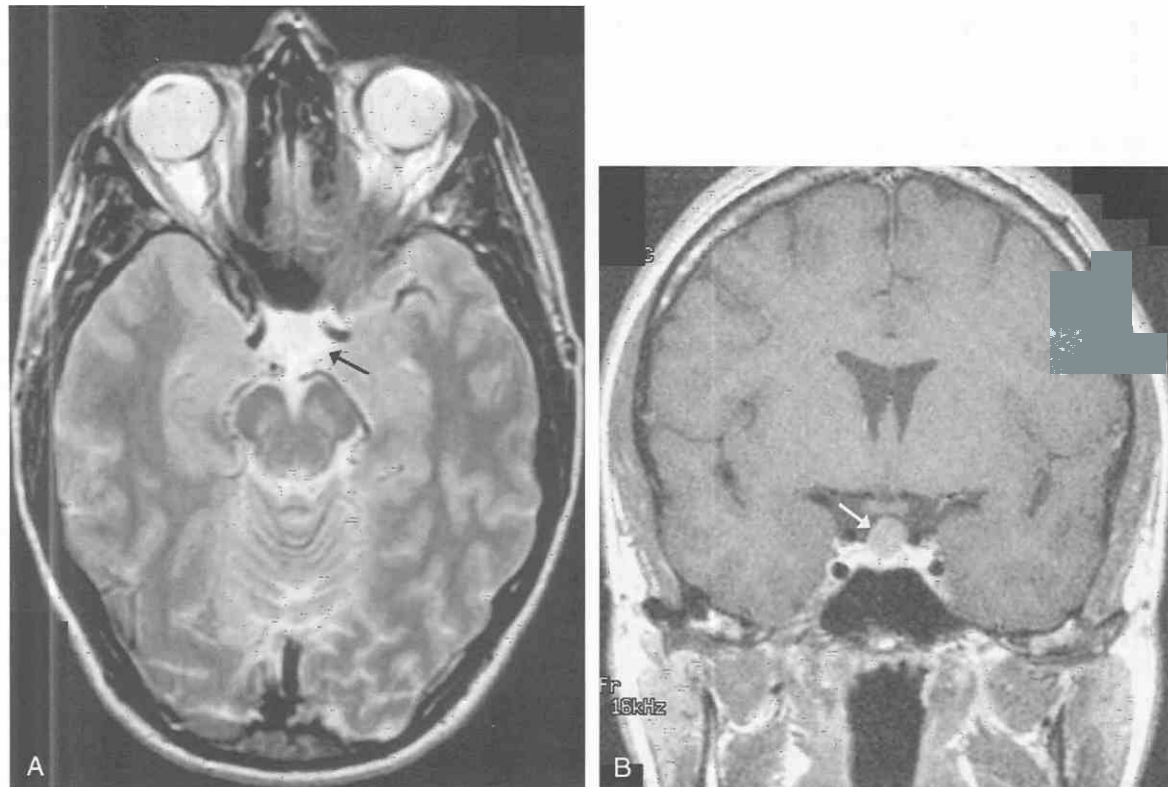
Rathke cleft cyst. Axial T2-weighted (A) and coronal postgadolinium T1-weighted (B) images demonstrate a small smoothly margined cystic mass (arrows) within and projecting above the pituitary gland. The cyst appears slightly hyperintense relative to gray matter on both T1-weighting (B) and T2-weighting (A). There is no contrast enhancement of its contents or margins.
